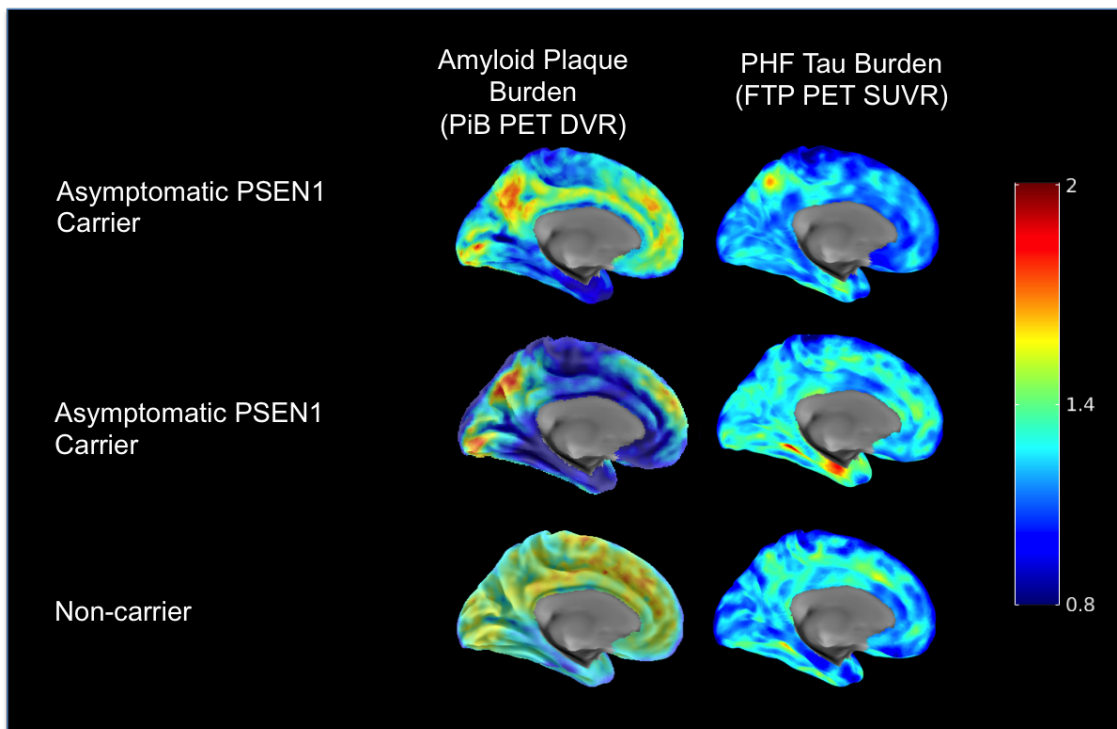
PET maps are shown for two cognitively unimpaired carriers (MMSE>27) and one age-matched non-carrier family member. Sagittal PiB DVR maps are shown on the left, and sagittal FTP SUVR maps are presented on the right. Images are displayed in standardized atlas space, along with whole-brain surface renderings, with a left hemisphere view. Row (A) A cognitively unimpaired carrier with high cortical amyloid (DVR=1.39) and with FTP binding in entorhinal cortex (SUVR=1.35). (B) A cognitively unimpaired carrier with higher cortical amyloid (DVR=1.41), and FTP binding in entorhinal cortex (SUVR=1.12). (C) An age-matched unimpaired non-carrier with low amyloid by PiB PET (DVR=1.10) and low FTP binding in entorhinal cortex (SUVR=1.11). PET: positron emission tomography, MMSE: Minimal State Examination, PiB: Pittsburgh Compound B, DVR: Distribution volume ratio, FTP: Flortaucipir, SUVR: Standardized uptake value ratio.
